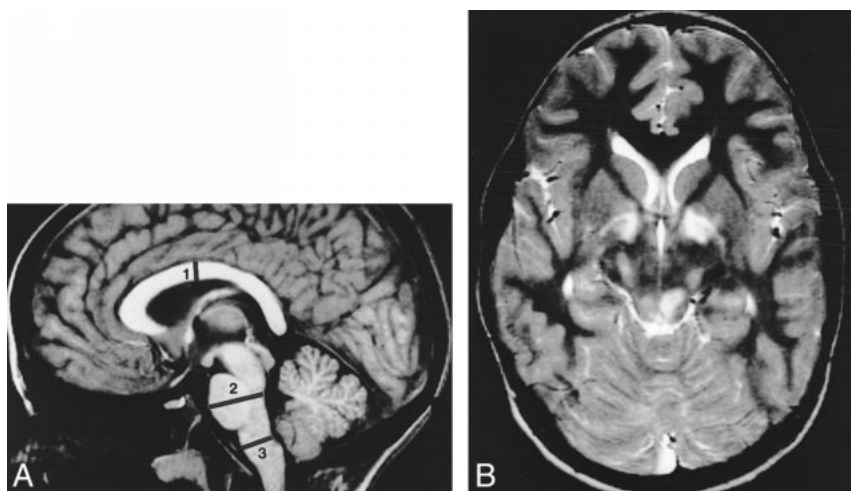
A, T1-weighted sagittal midline image (266/6/3) in an 11-year old boy with NF-1 and macrocephaly shows where the measurements of midline structures were made (see Table 2). This boy had thickening of the corpus callosum and enlargement of the anteroposterior diameter of the pons and medulla.
